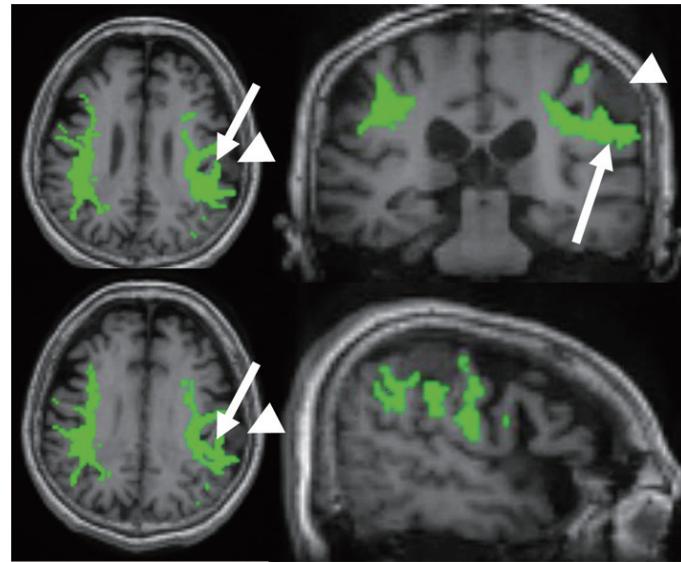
DTI images of the SLF before surgery. The SLF (green) was constructed in axial (Panel 1) and coronal (Panel 2) MRI as described in the Methods section. The left SLF ran around the tumor (white arrowhead), and one branch of the left SLF (white arrow) was highly compressed by the tumor.
